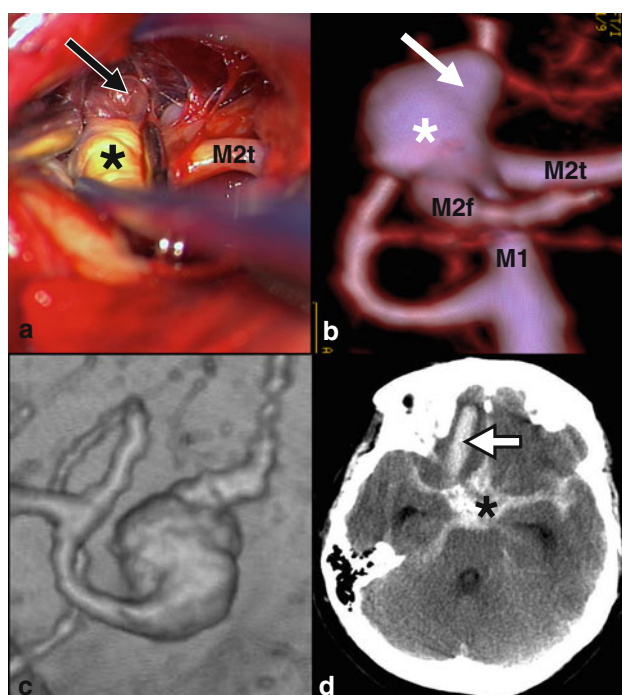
a Fundus of a ruptured aneurysm at the middle cerebral artery (exposed via partial opening of the fissura Sylvii in a patient with SAH) and b computed tomography angiogram (CTA) of the same aneurysm. This aneurysm has a thick-walled part (*asterisk*) and a thin-walled secondary protrusion (*arrow*) that is the most likely bleeding site. M2f refers to the frontal branch and M2t to the temporal branch of the middle cerebral artery. c A fusiform aneurysm, a segmental dilatation of a vessel, at the distal posterior cerebral artery (CT angiogram). d Rupture of a saccular or fusiform intracranial aneurysm can cause subarachnoid hemorrhage (*asterisk*) and intracerebral hemorrhage (*arrow*) (computed tomography, blood in *white*)
